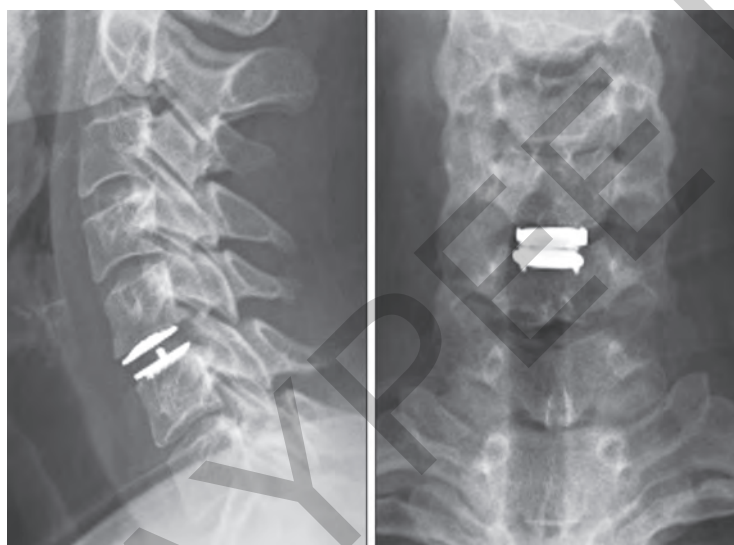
Lateral (left) and AP (right) radiographs obtained at 1-year follow-up. Implant position is appropriately maintained and there is no evidence of adjacent segment degeneration (AP: anteroposterior).
